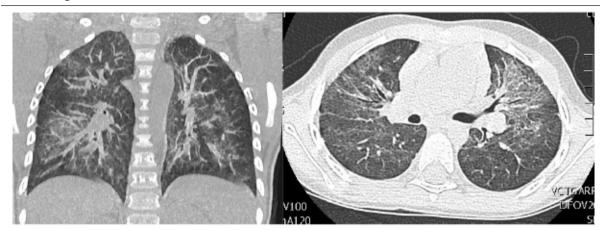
High-resolution chest CT scan at 12 months
